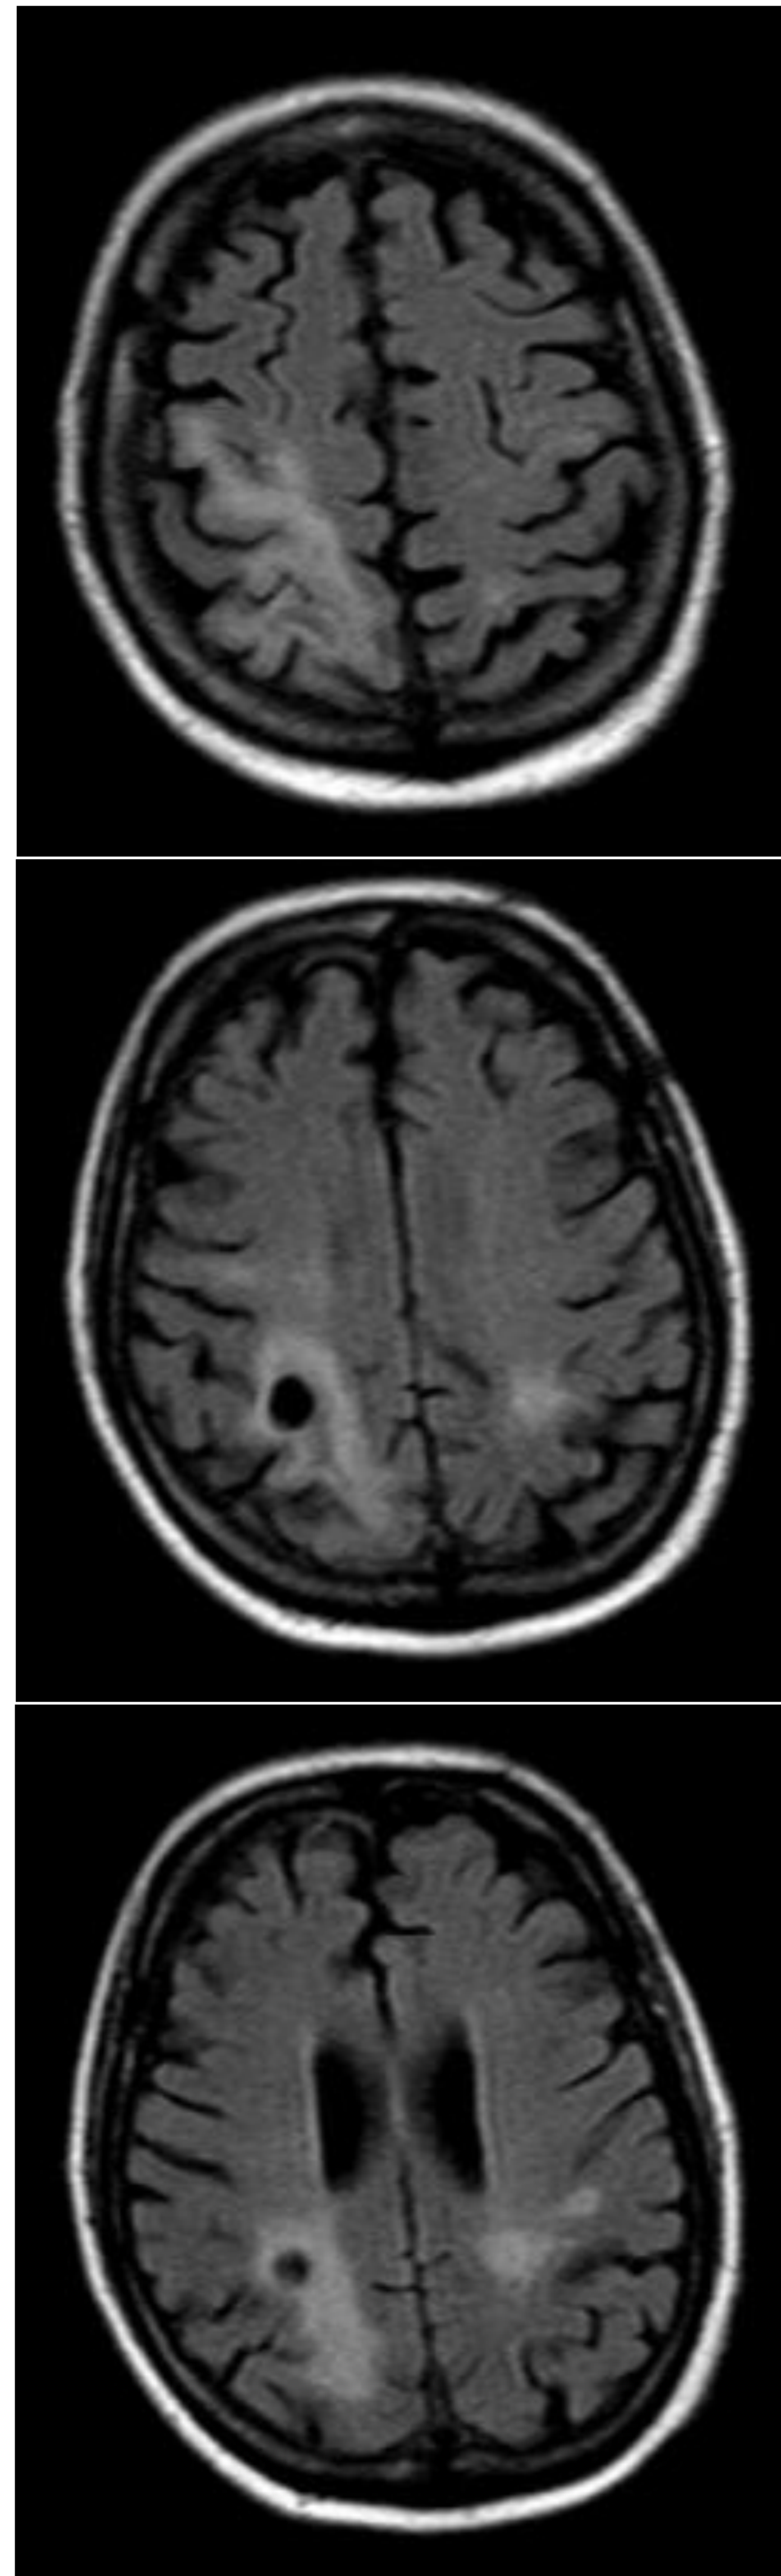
MRI Brain- right parietal focus and enhancement
